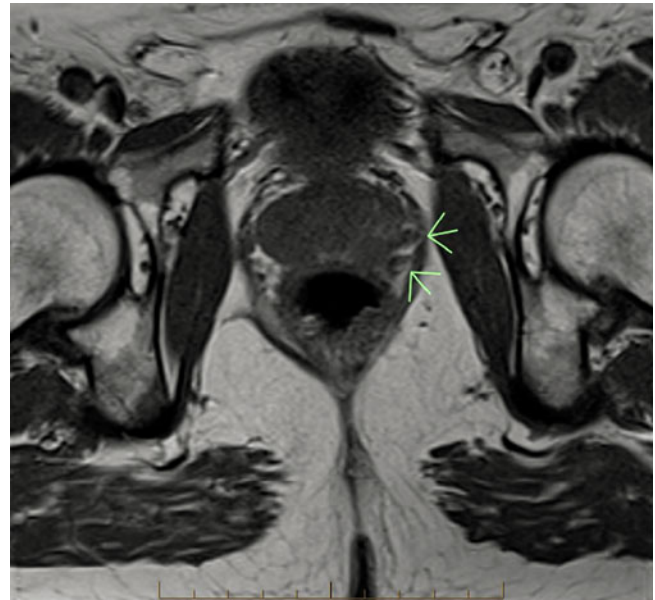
MRI demonstrating potential extracapsular extension in PCa nodules (*arrows*) of a patient with only 2/14 cores positive with PCa who may now not be suitable for active surveillance despite clinically having organ-confined disease (Image courtesy of Dr. George Koulouris, Melbourne Radiology Clinic, Australia)
